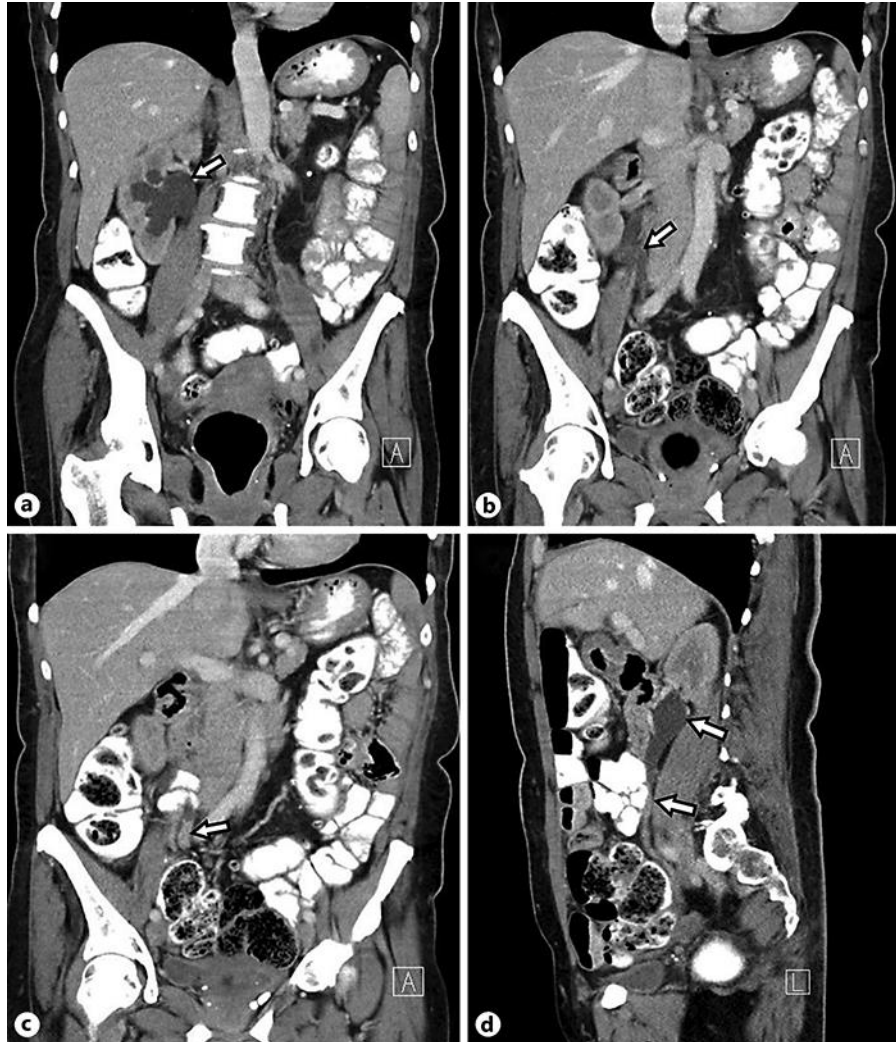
a–d Abdominal CT scan showing hydronephrosis (arrows) on the right (a, b, d), caused by a mass (arrows) in the middle third of the ureter (c, d).
